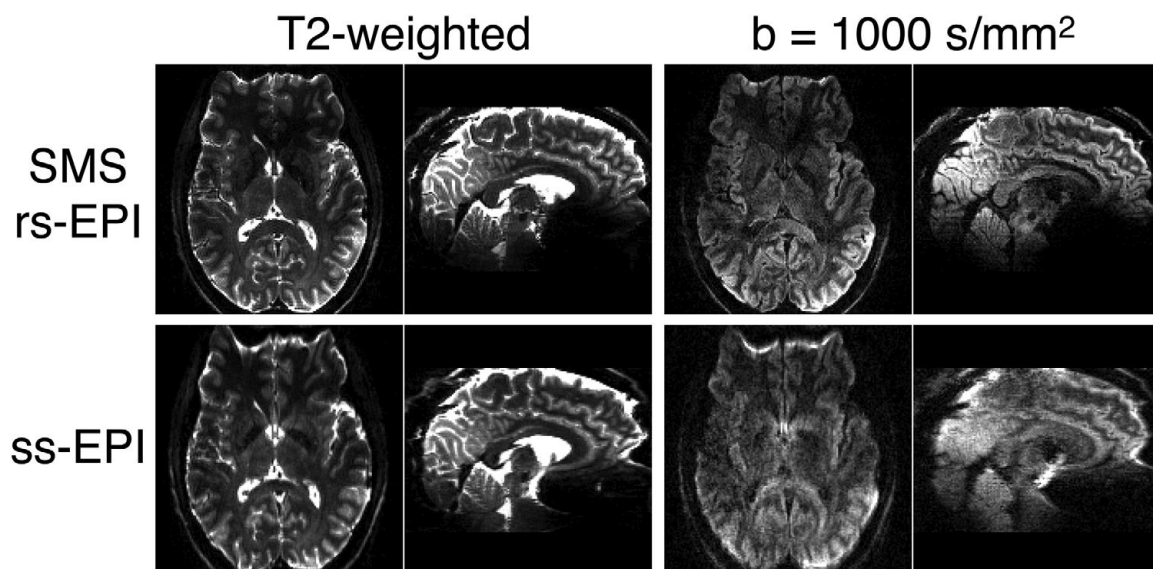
(from Frost 2015) Examples of raw T2-weighted and b=1000 s/mm² images acquired at 7T with single-shot EPI (ss-EPI) and SMS readout-segmented EPI (SMS rs-EPI) DTI protocols with 1.2 mm isotropic resolution
